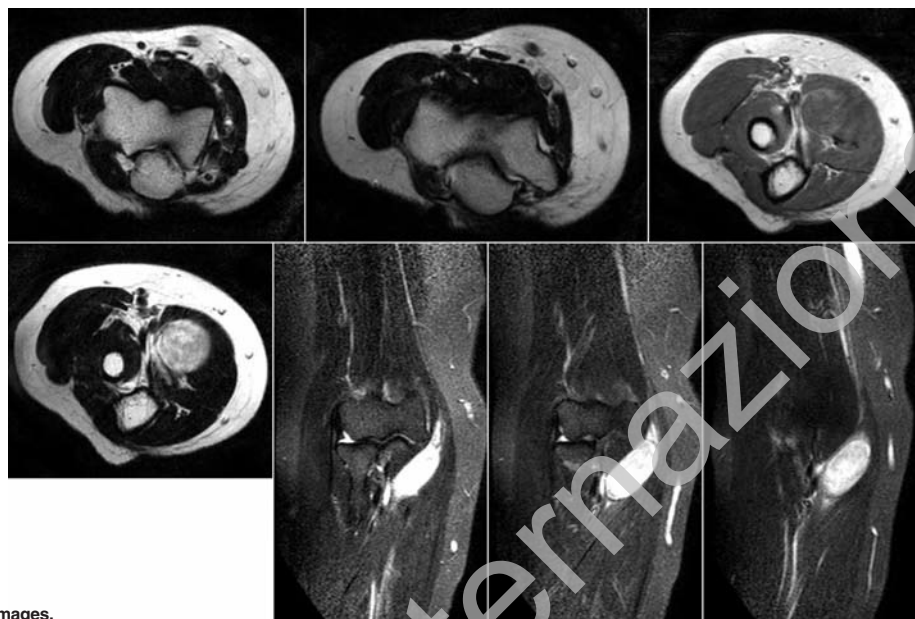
Preoperative magnetic resonance images.
